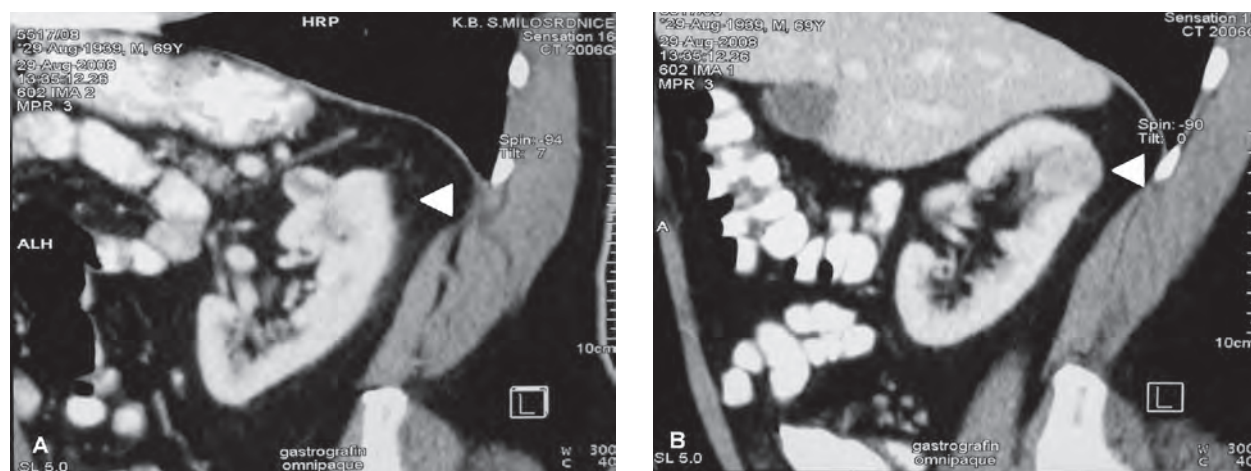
CT scan revealing the presence of oval tumors in the upper pole of the right (A) and left (B) kidneys. Arrows pointing to the tumor site.
